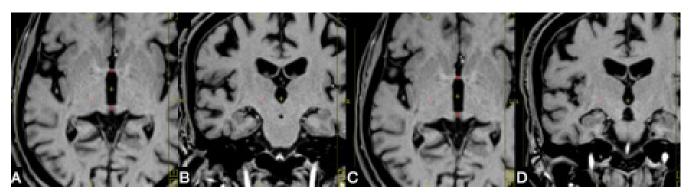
A case of a 56 years old male patient with PD planning for right unilateral combined VIM and GPi lesioning. (A) Axial MRI brain T1WI with VIM target "red crosshair right to third ventricle". (B) Coronal MRI brain T1WI with VIM target "red crosshair right to third ventricle". (C) Axial MRI brain T1WI with GPi target "red crosshair right to third ventricle". (D) Coronal MRI brain T1WI with GPi target "red crosshair right to third ventricle".
